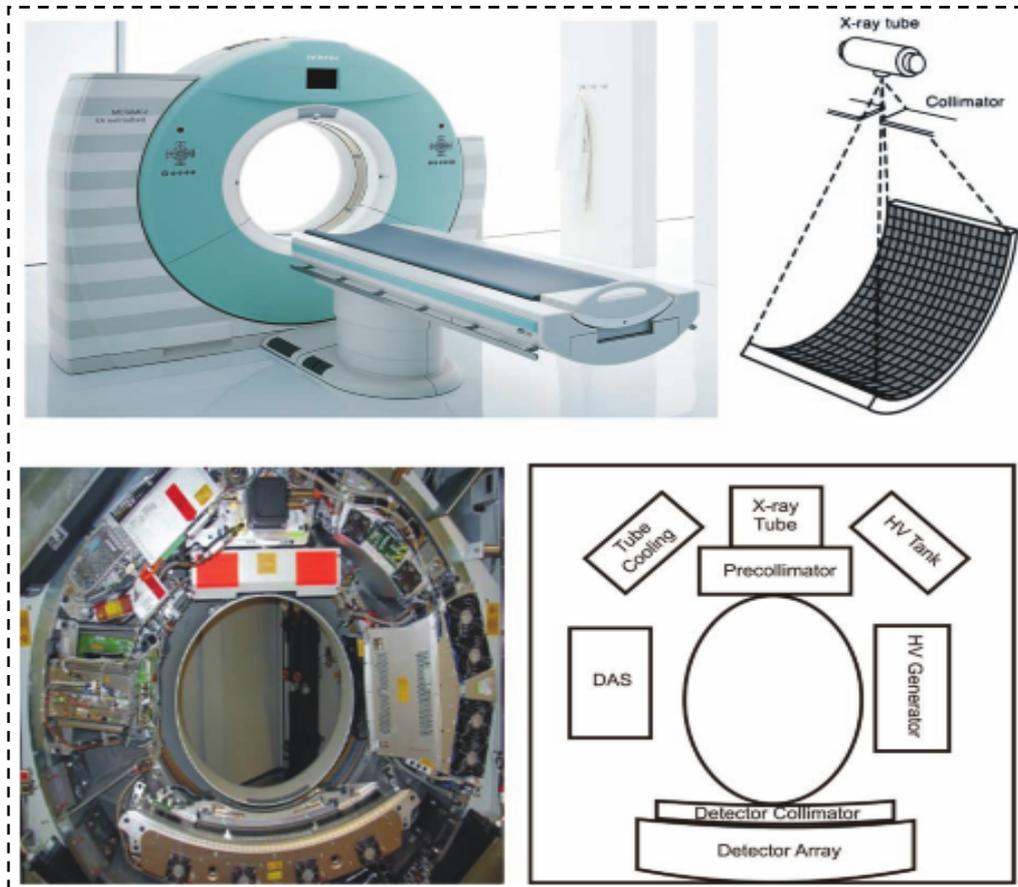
A modern CT scanner. [15]
